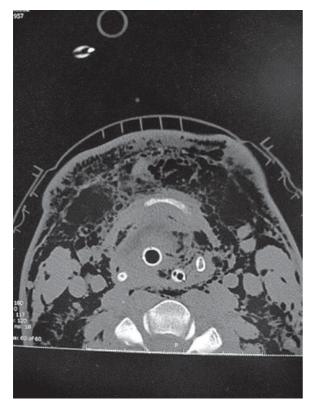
CT scan shows that there is extensive subcutaneous emphysema, and the airway cannot be identified
